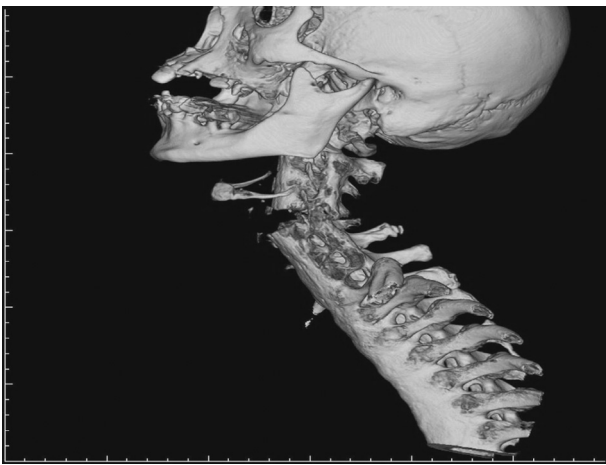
In the 3D reconstruction image of CT scan of cervical spine, a distinct picture of fused spine and extension fracture were demonstrated.
